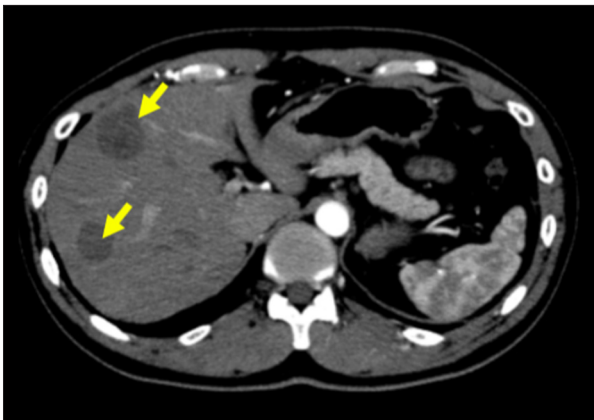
Contrast-enhanced computed tomographic scan showing metastatic lesions in the right lobe of the liver (yellow arrows).
